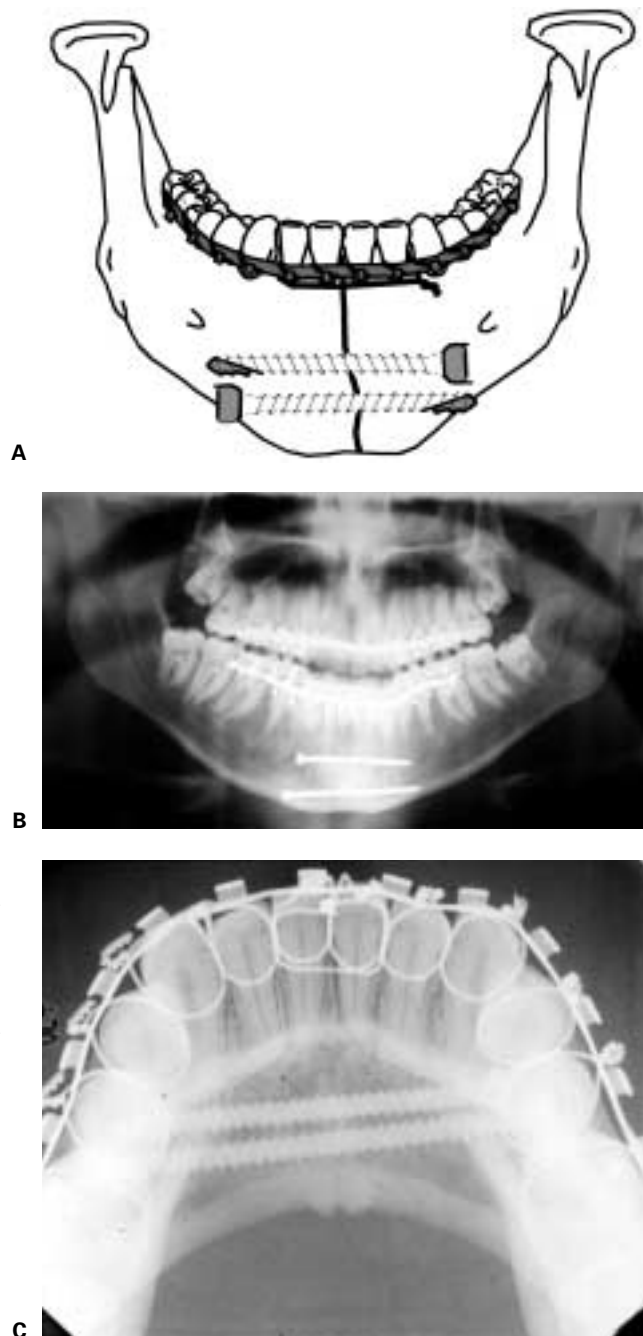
Lag screw technique for anterior mandibular fractures. (A) Placement of two lag screws from one buccal cortex to the other for a sagittal fracture of the mandible. (B) Panoramic and (C) occlusal radiographs showing postoperative result.
